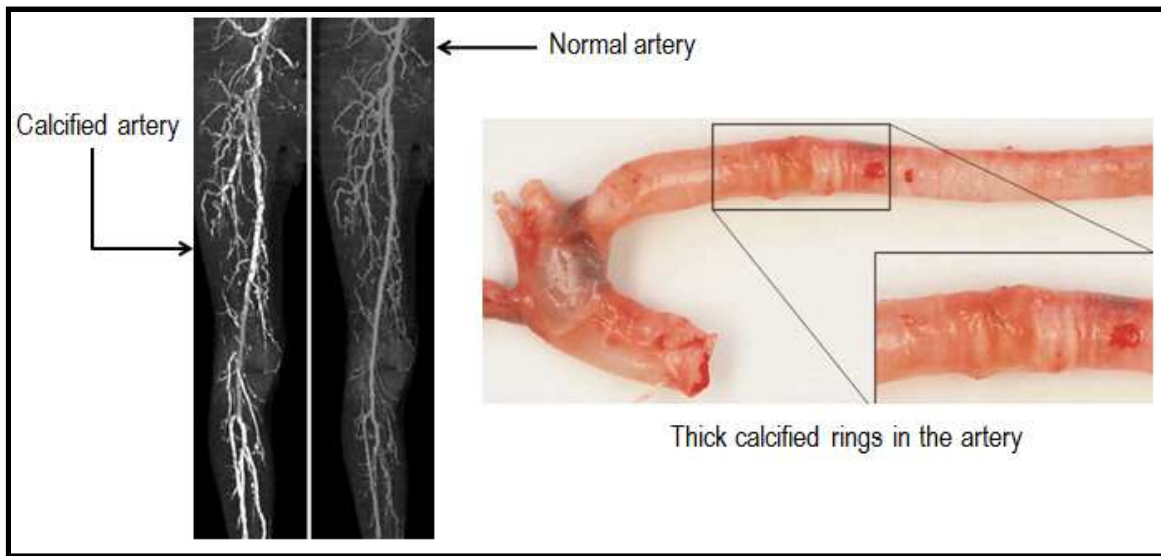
Normal arteries seen do not block x-rays whereas calcified arteries display the railroad pattern of calcific deposits, visualized as white thick calcified rings upon gross examination.^{79,80}
